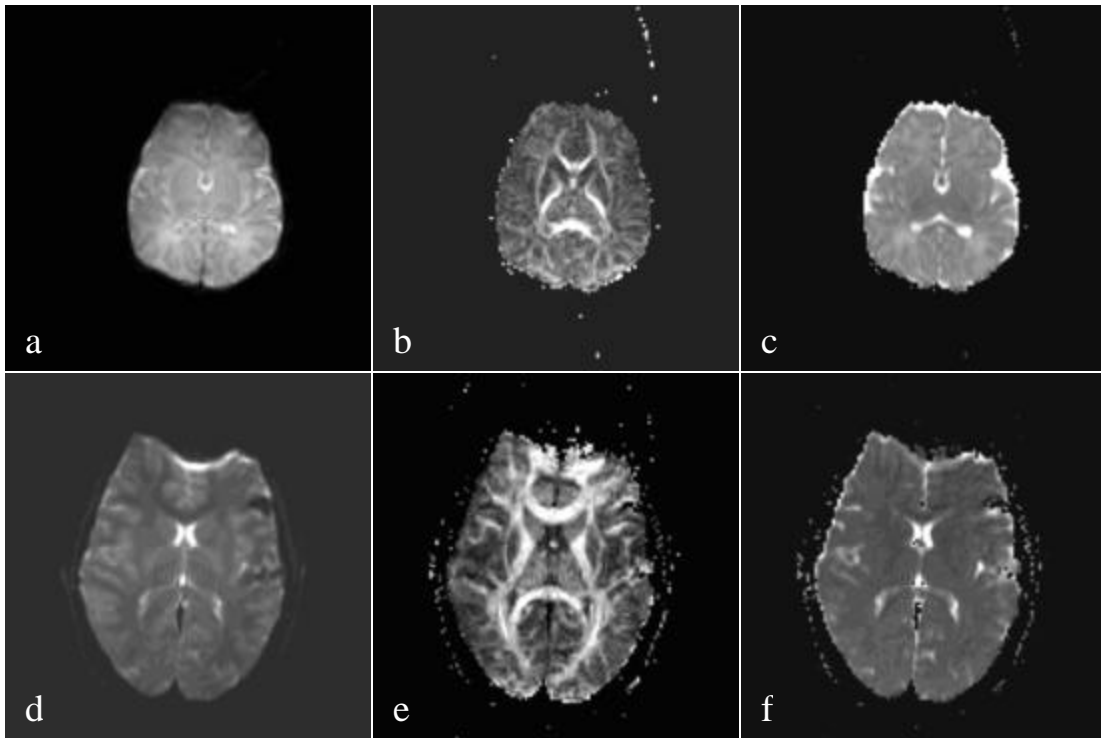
Comparisons of T2-weighted images (a and d), FA maps (b and e), and ADC maps (c and f) between the neonate (upper row) and the adult (lower row) are shown.
